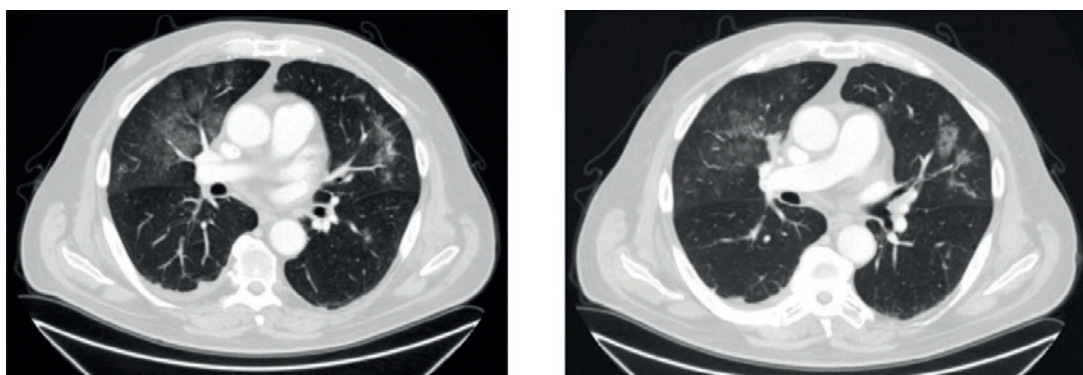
Computed tomography scan of an angiosarcoma case with metastatic spread.
